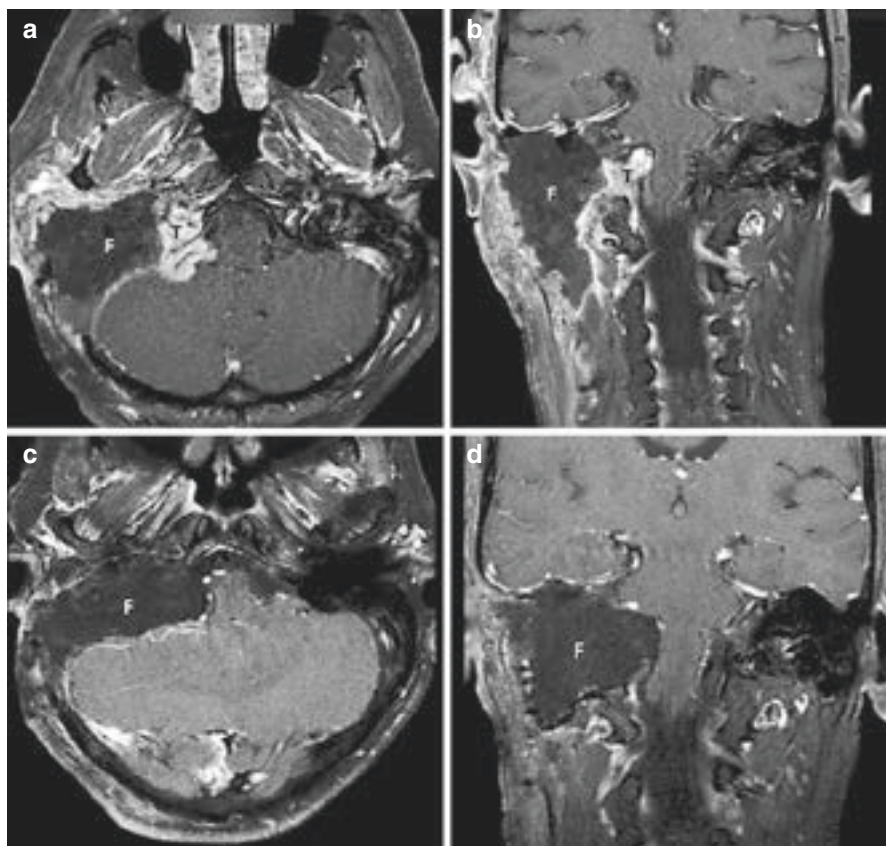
(a, b) MRI, axial, and coronal views after the first-stage surgery. The residual intradural tumor is noted. The surgical defect is filled with abdominal fat. *T* intradural tumor, *f* fat. (c, d) MRI, axial, and coronal views after the second-stage surgery. After the surgery, there is no residual tumor
